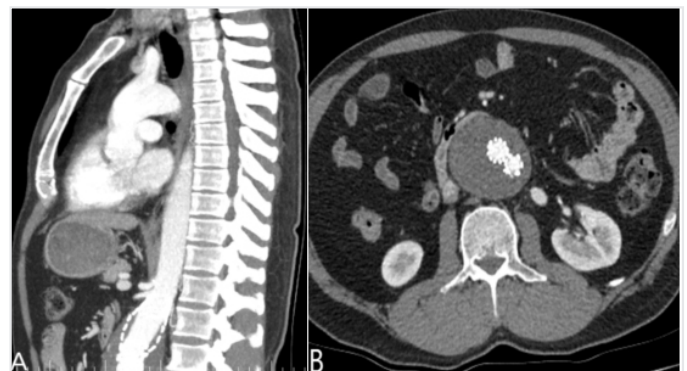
Postoperative sagittal (A) and axial (B) computed tomography (CT) angiography sections showing stent material in the abdominal aorta starting from the renal level and extending into both the common iliac arteries. In contrast to the upper vertebral arteries, the second pair of the lumbar arteries did not appear normal
